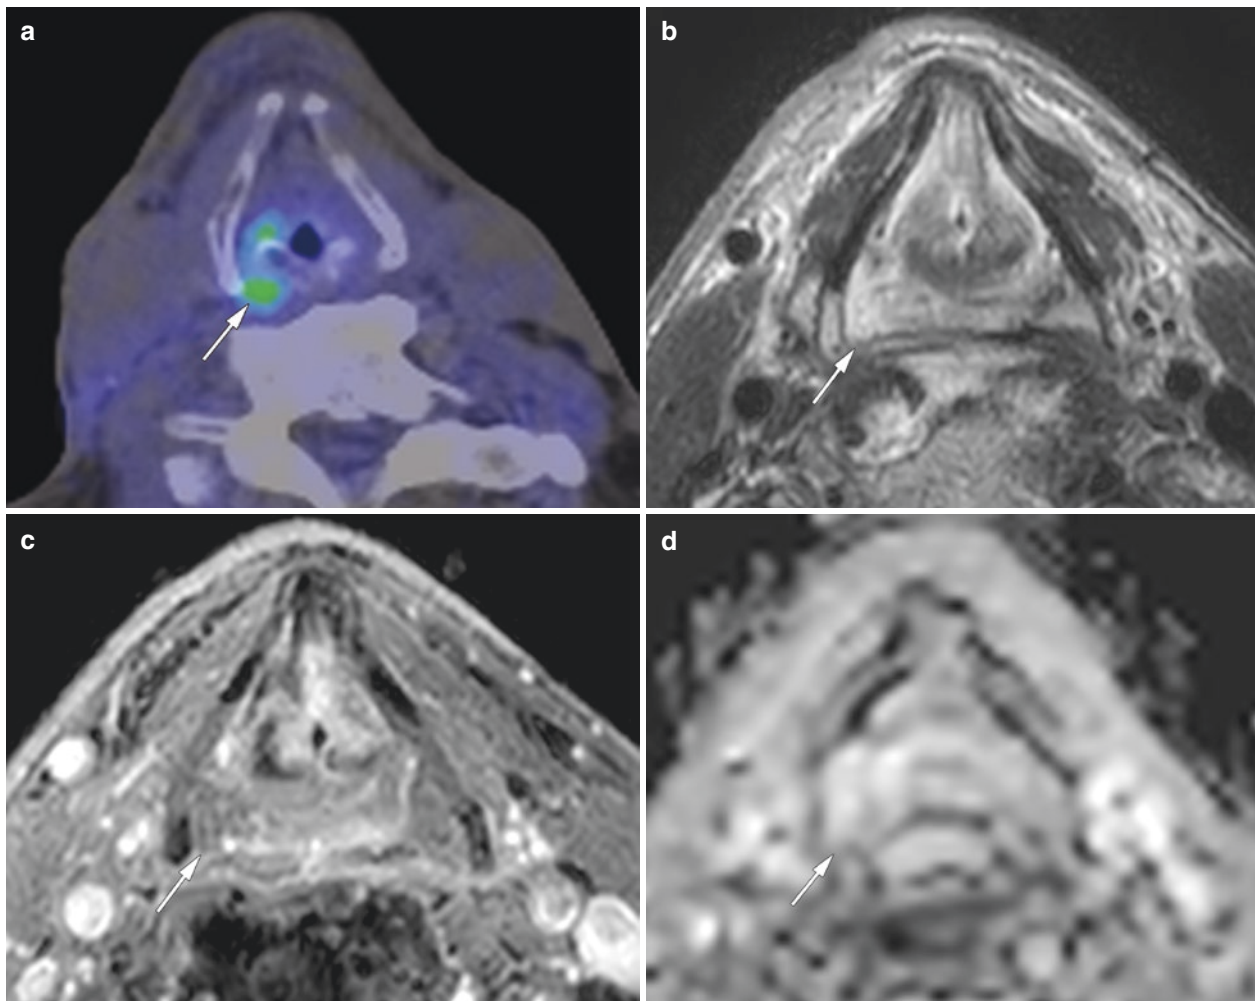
True negative findings for primary site by MRI with hypopharyngeal cancer treated by chemoradiation therapy. On the FDG-PET (a) and MRI (b–d) obtained 3 months after CRT for pyriform sinus cancer. FDG-PET showed FDG uptake at the primary site. However, axial T2-weighted image (b) and contrast-enhanced T1-weighted image
